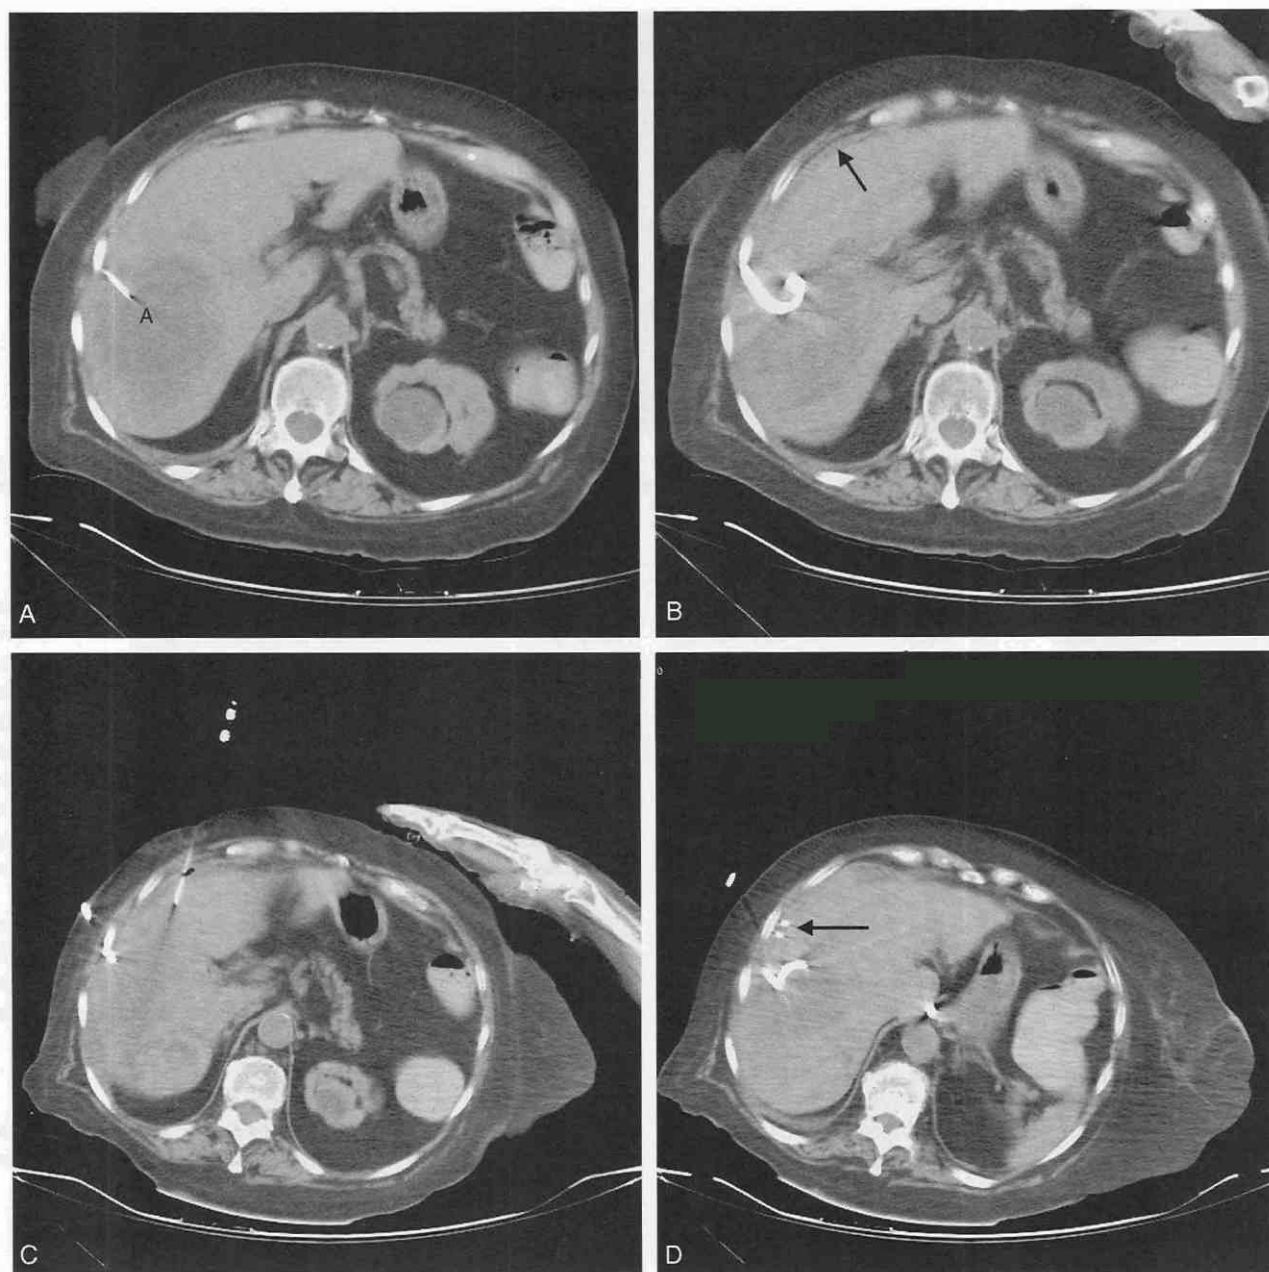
A, CT scan shows puncture of intrahepatic abscess (A) through a midaxillary line location. Because a cuff of normal liver was used, no leakage occurred at this time. B, After insertion of the large catheter (arrow), it was noted that a leakage of purulent material occurred into the subphrenic space (arrow). C, Puncture of the small subphrenic fluid was performed. When such punctures are attempted, they should be planned obliquely and so that the needle penetrates beyond the space. The instrument is withdrawn while suction is applied; the location of the tip in the space is heralded by aspiration of fluid. The wire and catheter are then inserted. D, Because of the small space, repeat scan is important to confirm the location of the catheter in the space (arrow).
